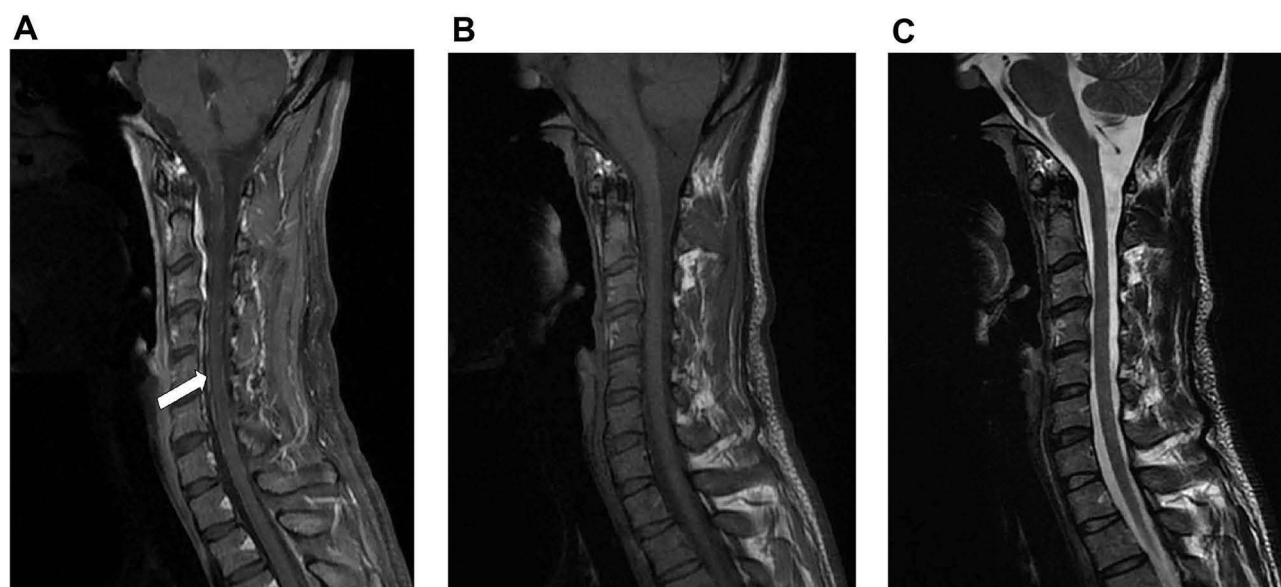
Cervical spine MRI scan of neurosyphilis patients with LESC showed linear enhancement of leptomeningeal surface lesions in T1 hyperintensity. (A) Sagittal T1-postgadolinium images reveal leptomeningeal enhancement (arrow). (B) T1-weighted sagittal image. (C) T2-weighted sagittal image.
